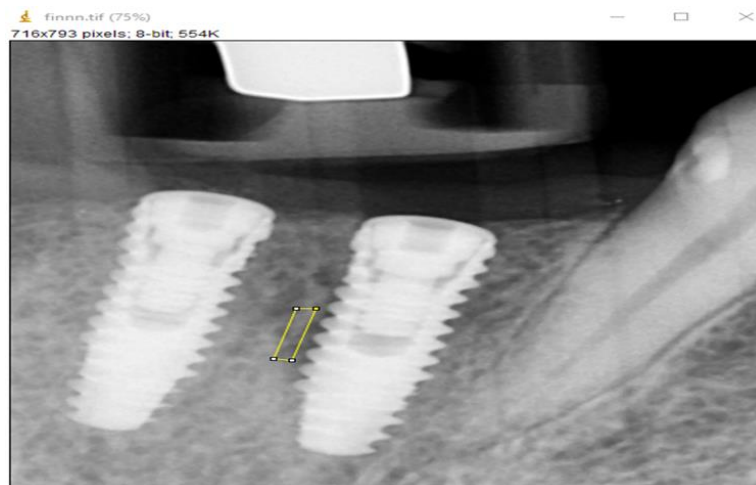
Digital periapical image demonstrating the ROIs used to calculate the FD.
